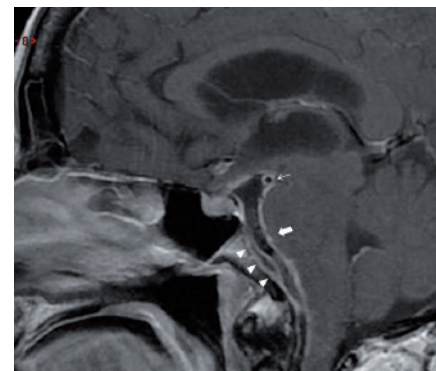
T1 Sagittal MRI with gadolinium showing ventricular dilatation, basal arachnoiditis (thick arrow), perivascular enhancement (thin arrow) and a dural collection dorsal to the clivus (arrow heads).
